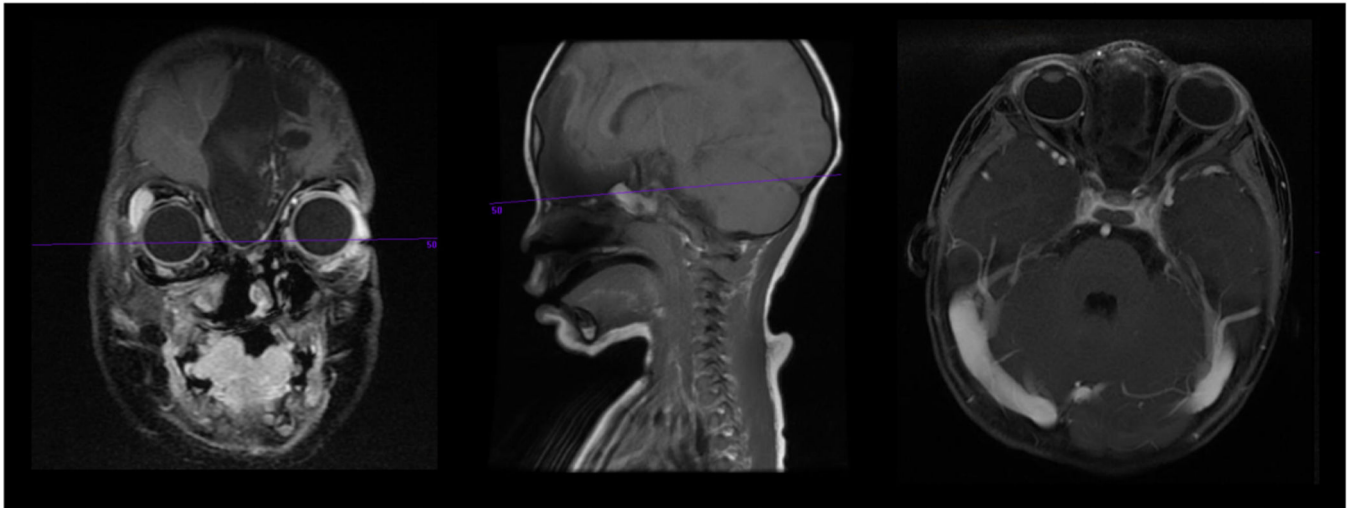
MRI prior to trans-nasal resection.
